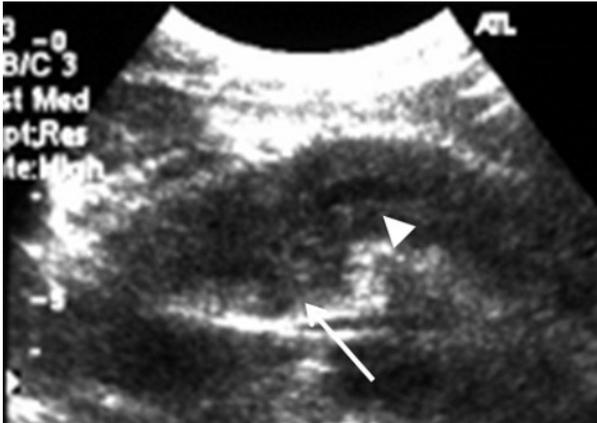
Abdominal ultrasound showing a low echoic mass (arrow) with dilatation of the mild main pancreatic duct (arrow head) in the pancreatic head.
